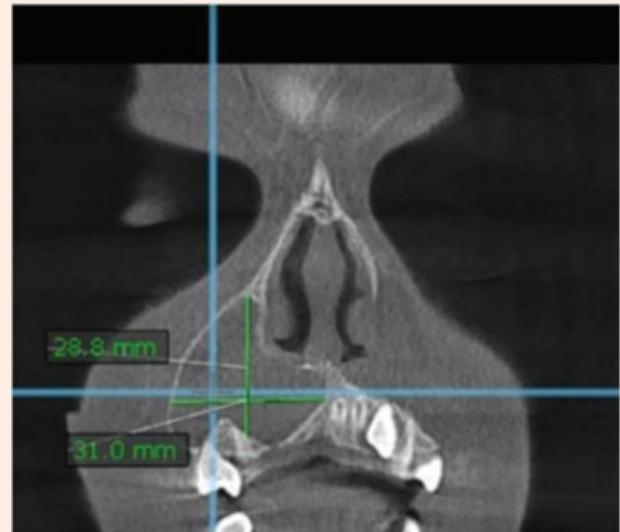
CBCT of maxilla showed a well-defined radiolucency with buccal cortical plate thinning and expansion, displacing the floor of maxillary sinus with impacted 13.
